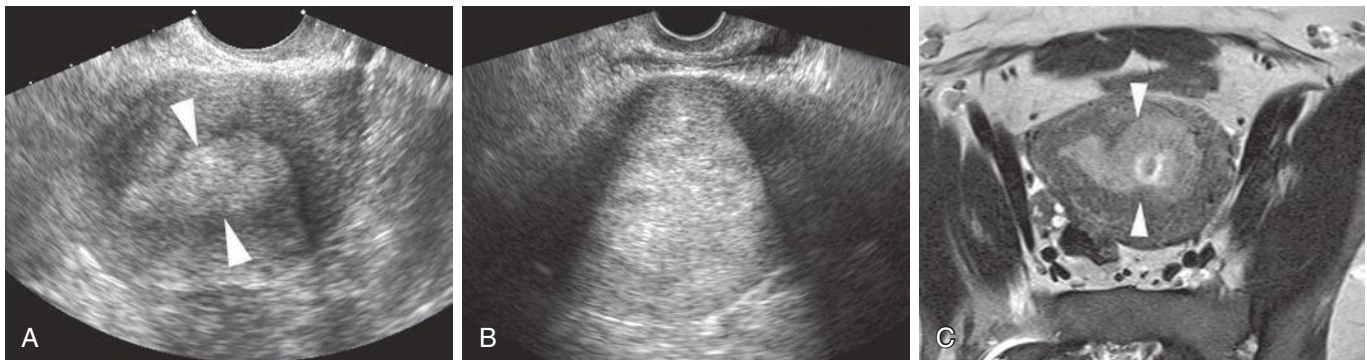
A 26-year-old premenopausal obese woman with dysfunctional uterine bleeding. A, Transverse transvaginal sonography (EVS) image of the uterus demonstrates irregular and asymmetric echogenic thickening of the endometrial echo complex (*arrowheads*). Dilatation and curettage (D&C) was performed, showing chronic endometritis but no evidence of malignancy. B, EVS performed 2 years later in the setting of continued abnormal bleeding shows increased endometrial thickening with an ill-defined endometrial-myometrial interface. Given the results from prior D&C, magnetic resonance imaging was performed. C, Axial oblique T2-weighted image of the uterus shows mass-like irregular thickening of the endometrium (*arrowheads*) with less than 50% thickness myometrial invasion. Hysterectomy confirmed stage 1A endometrial carcinosarcoma.
